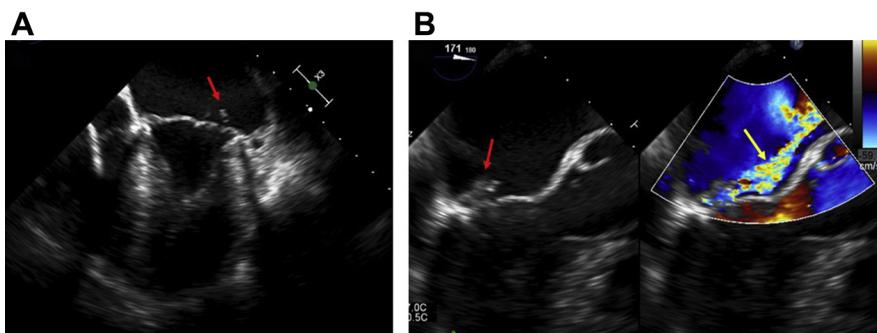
Transesophageal echocardiogram (TEE). TEE with (A) flail P2 scallop of the mitral valve leaflet (arrows) with (B) resultant severe, eccentric anteriorly directed mitral regurgitation (MR) with entrainment/Coanda effect (arrow).
